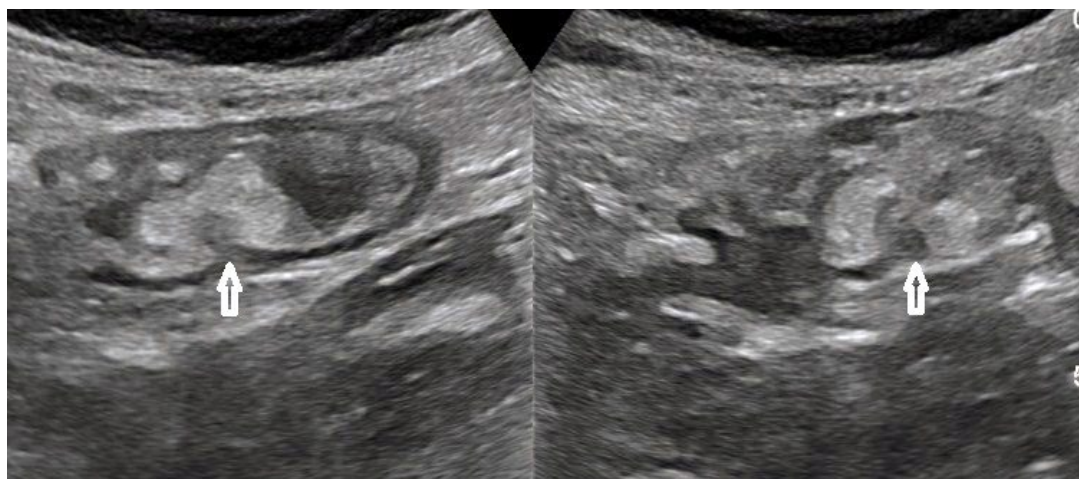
A. The arrows point to the two lips of the ileocecal valve in front of which a bezoar (irregular echogenic cluster) has stopped. B. The same bezoar. Color Doppler revealed color twinkling artifacts in the bezoar
